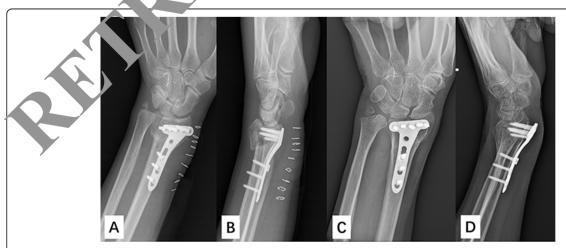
Case 1. Significant loss of volar tilt was observed at 12-months' follow-up. A, B: Postoperative posteroanterior and lateral radiographs at 12-months' follow-up
